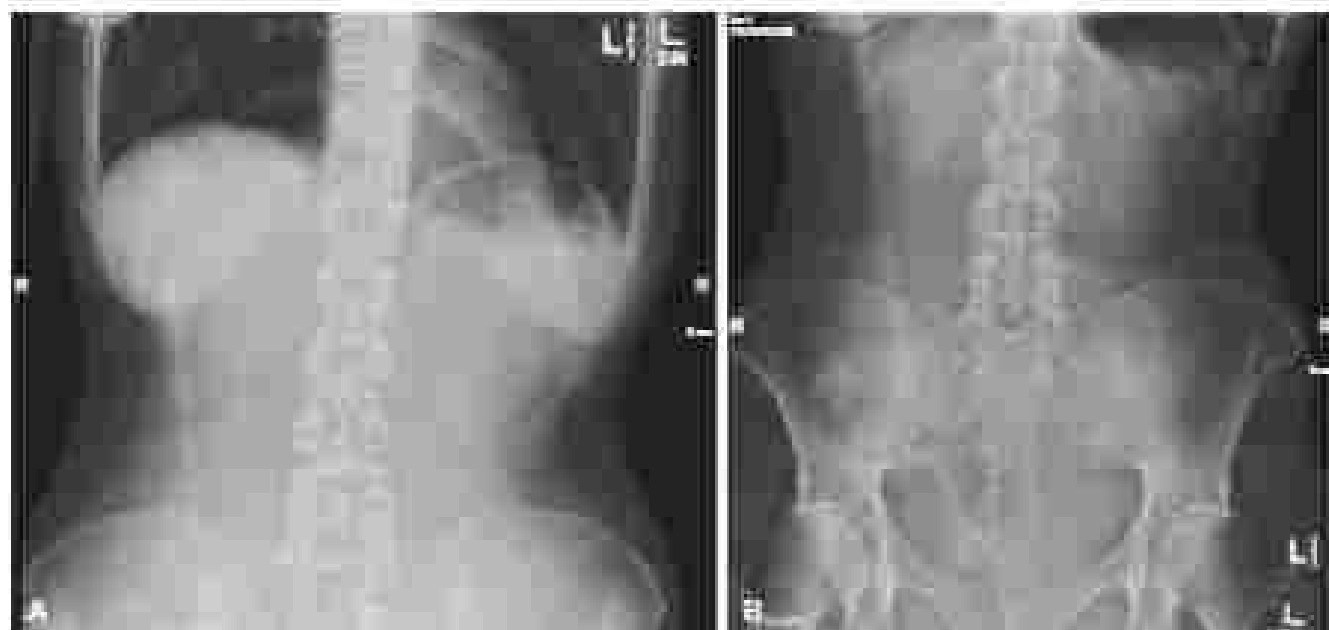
Abdominal radiograph demonstrates a "gutter atelectasis" in the upper (A) and lower (B) abdomen of a patient with small bowel obstruction.
